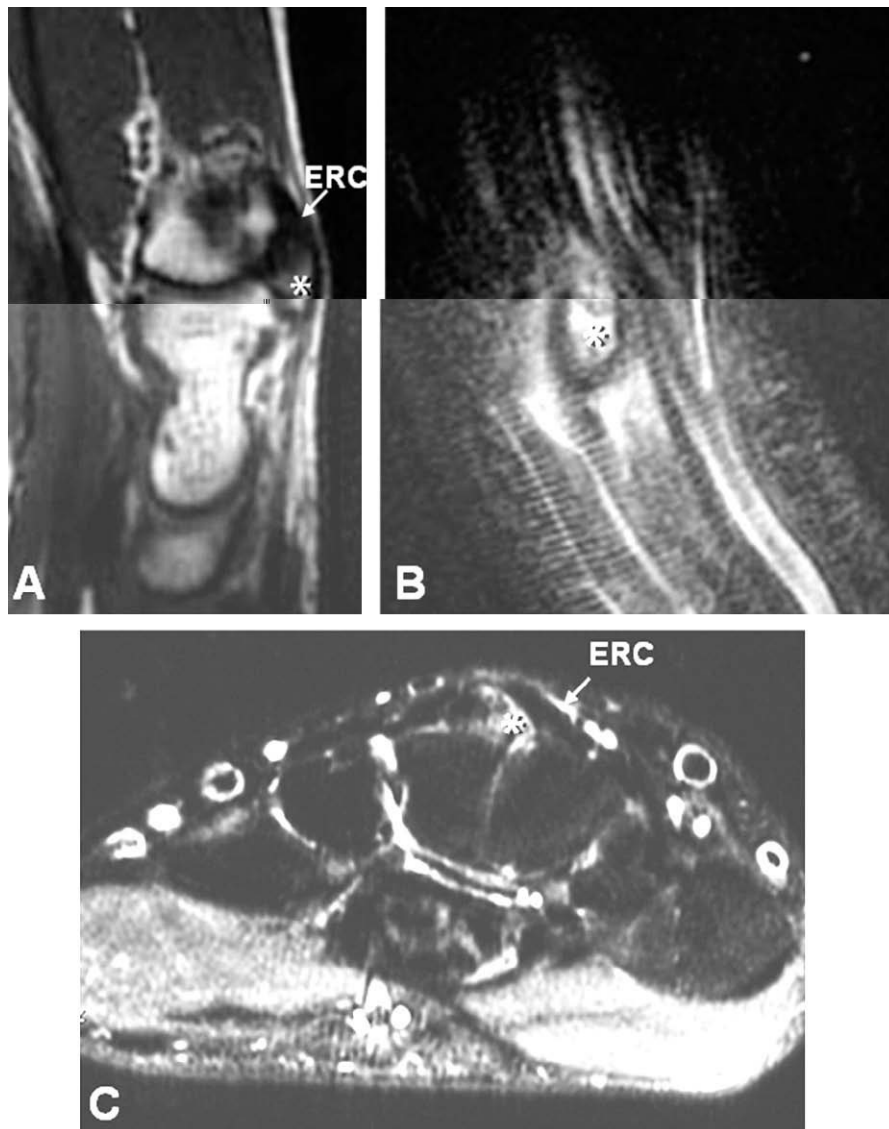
Magnetic resonance. A) Sagittal T1-weighted sequence showing the accessory bone (asterisk) articulating with the distal surface of the capitate bone and the base of the third metatarsal. Note that part of the entheses of the extensor carpi radialis brevis (ECRB) tendon lies slightly distal to the ossification area (arrow). The (B) and axial (C) fat suppressed proton density weighted sequences show the edematous hyperchoic styloid bone (asterisk) next to a small edema in the neighboring soft tissues and a peritendinitis-induced hyperchoic area surrounding the ECRB tendon.
